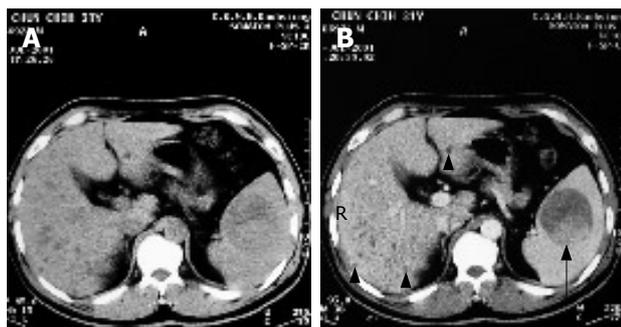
Abdominal CT. A: Non-contrast CT showed a well-defined tumor over the spleen; B: Contrast CT showed partial enhancement of the tumor with high density in the dorsal portion of the tumor (arrow) and multiple diffuse low-attenuation nodules in liver parenchyma (arrowhead).
